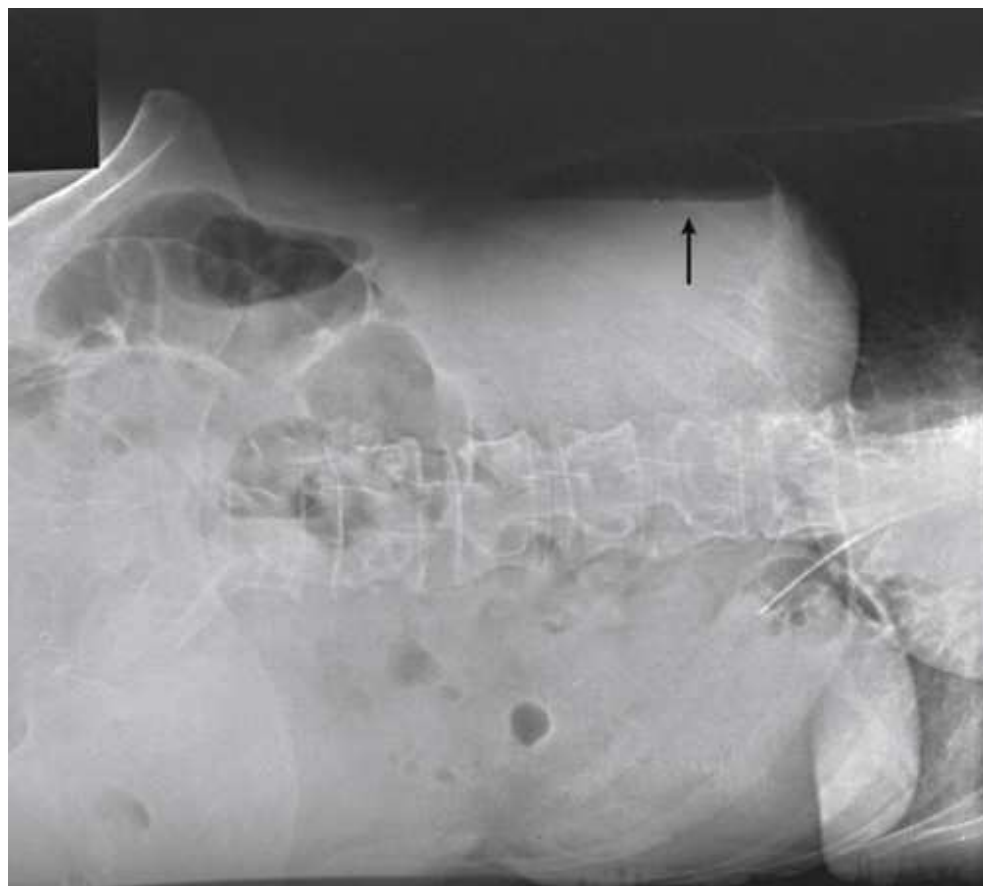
Left lateral decubitus position AP projection of abdomen performed on a trauma patient. Free intraperitoneal air is seen on upper right side of abdomen (*arrow*). Radiograph is slightly underexposed to show free air more easily.
